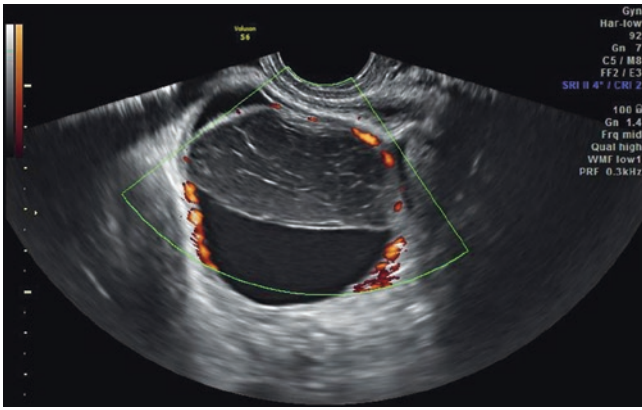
Transvaginal sonogram of the ovary: Hemorrhagic cyst on color Doppler sonography shows a dense halo of confluent vessels surrounding the cyst
